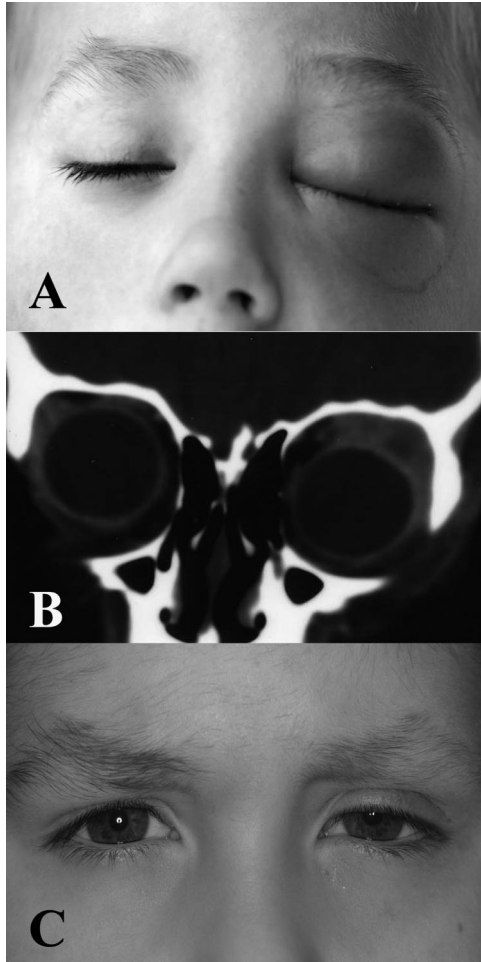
A, Six-year-old boy with acute left periorbital swelling; B, coronal CT image with superolateral infiltrate containing central lucency; C, reduced left periorbital swelling after radiotherapy and chemotherapy.
